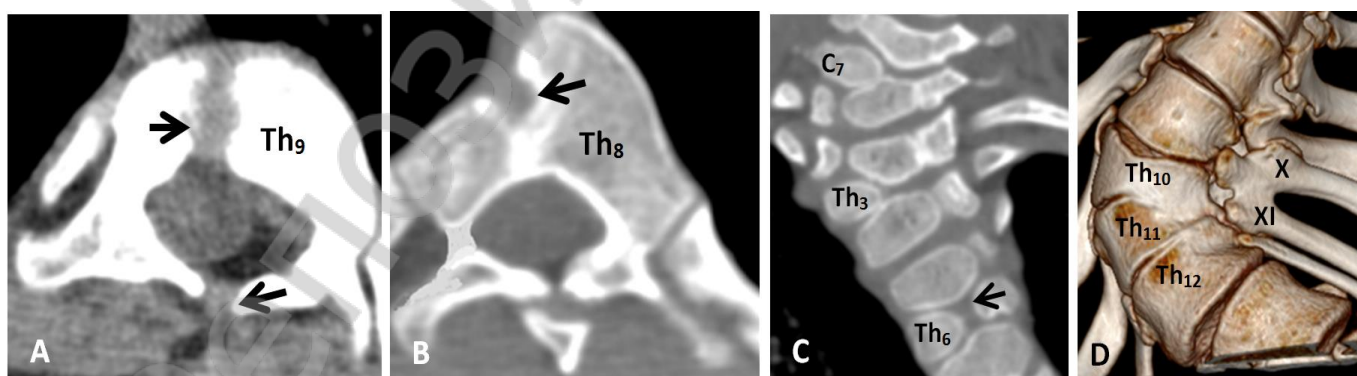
CT scans of the vertebral column. A – thoracic vertebrae (Th₉), with complete sagittal cleft of the body and spina bifida posterior (axial projection); B – incomplete sagittal cleft of the body of the eighth thoracic vertebra (axial projection); C – cervical C₈ and thoracic Th₃ hemivertebrae, butterfly vertebra Th₆ (3D-reconstruction of the thoracic spine, frontal view). D – block of the lower thoracic vertebrae bodies and arcs (Th₁₀-Th₁₂), intercostal block (X-XI) (3D - reconstruction of the thoracic spine, view of the left side). Bone defects are indicated by arrows.
